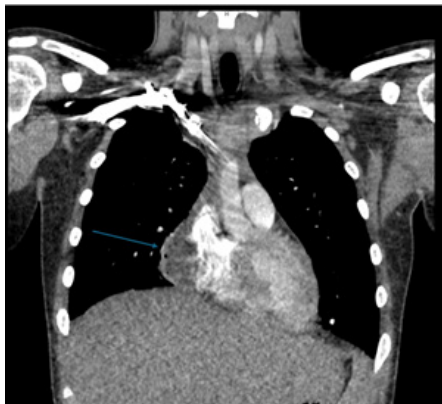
CT chest coronal view of the abscess in the right pericardial region.
